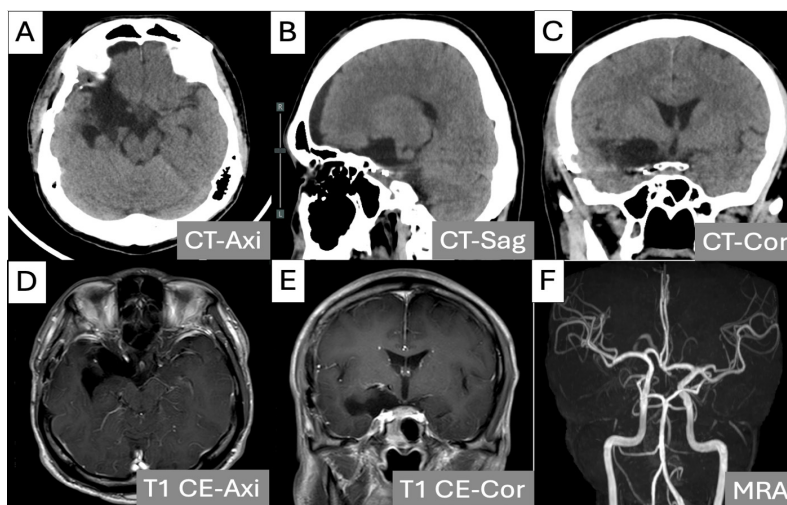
Postoperative CT scan on axial plane (A), sagittal plane (B), coronal plane (C) The tumor has been completely removed. Postoperative MRI with T1 with contrast injection on the axial plane (A), coronal plane (B) and tumor angiography is completely removed.
